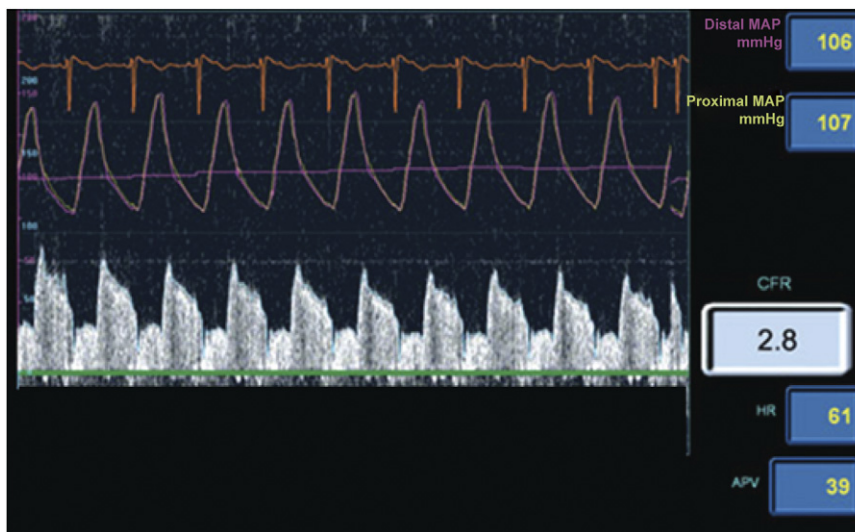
Example of Doppler Wire Tracing
